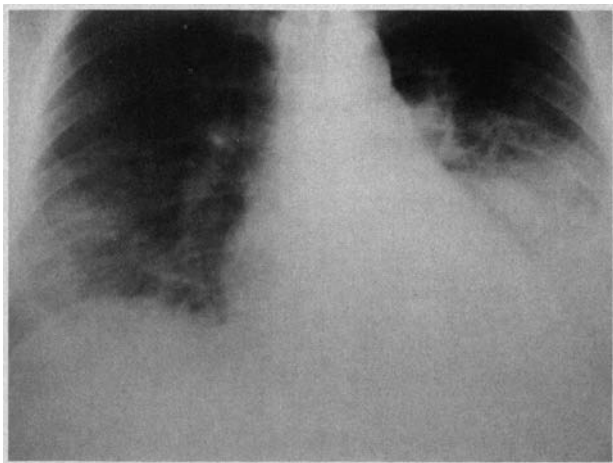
Patient's chest roentgenogram at admission showing bibasilar pulmonary infiltrates.
